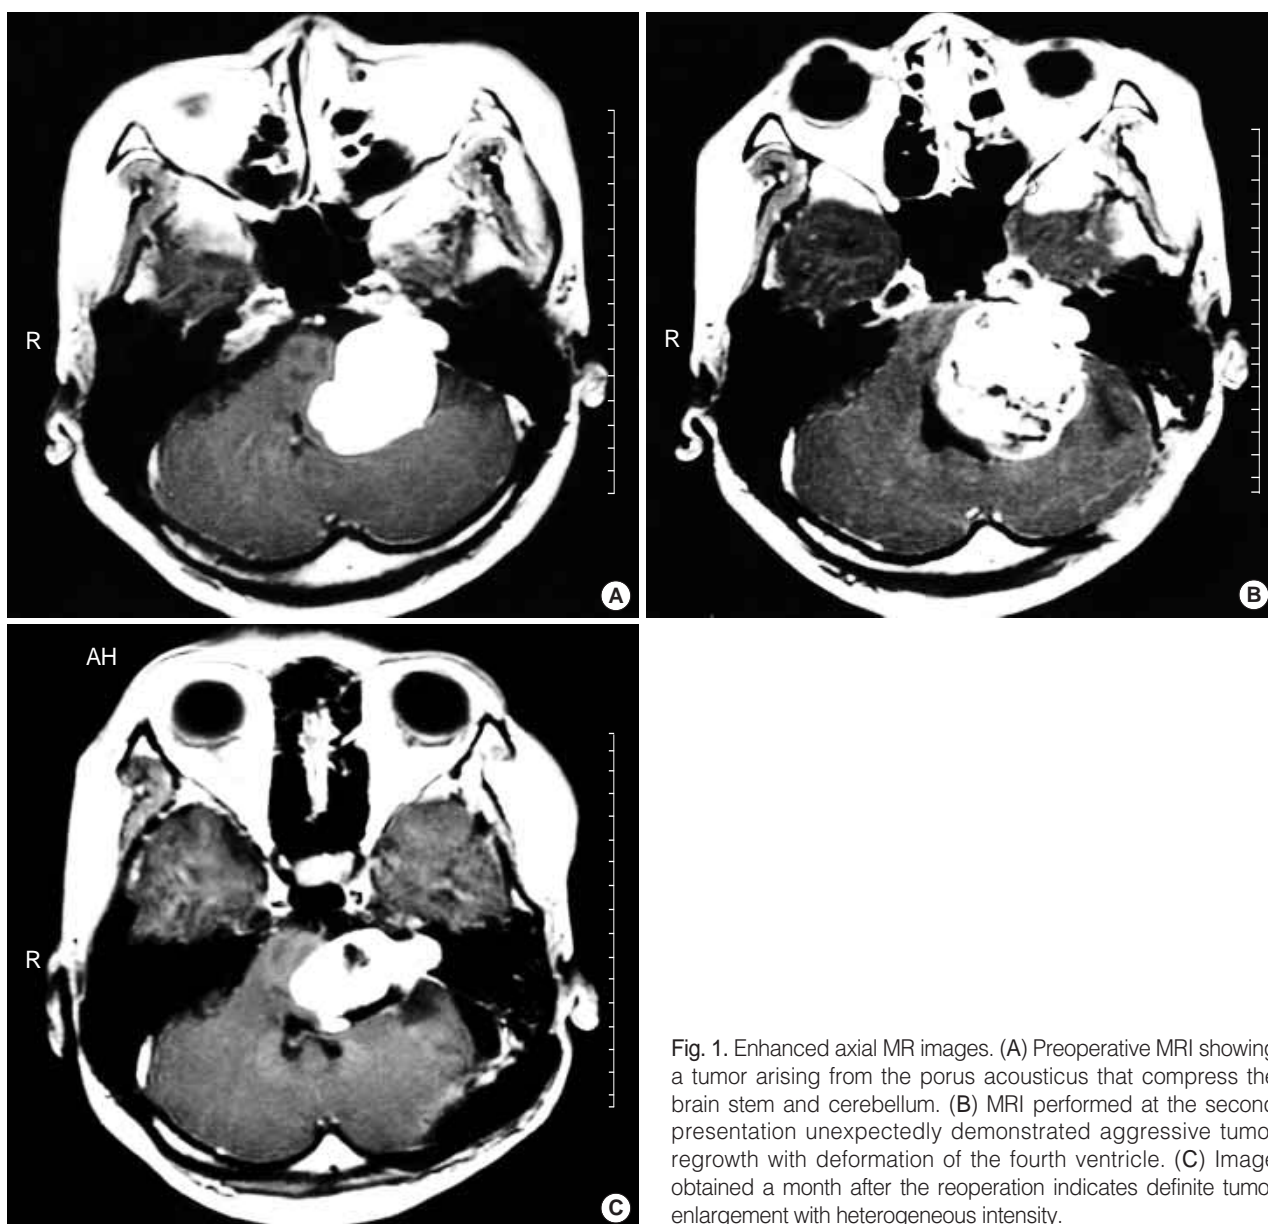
Enhanced axial MR images. (A) Preoperative MRI showing a tumor arising from the porus acusticus that compresses the brain stem and cerebellum. (B) MRI performed at the second presentation unexpectedly demonstrated aggressive tumor regrowth with deformation of the fourth ventricle. (C) Image obtained a month after the reoperation indicates definite tumor enlargement with heterogeneous intensity.
